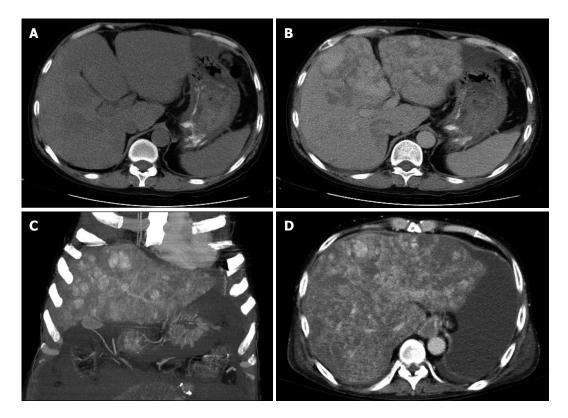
Liver dynamic computed tomography showing multiple liver tumors. A: Hypodense liver tumors before contrast injection; B: Heterogeneous enhancement in the arterial phase and portal venous phase after contrast injection; C: Follow-up computed tomography showing increased size of the hepatic lesion; D: Massive ascites observed at 4 mo after the follow-up.
